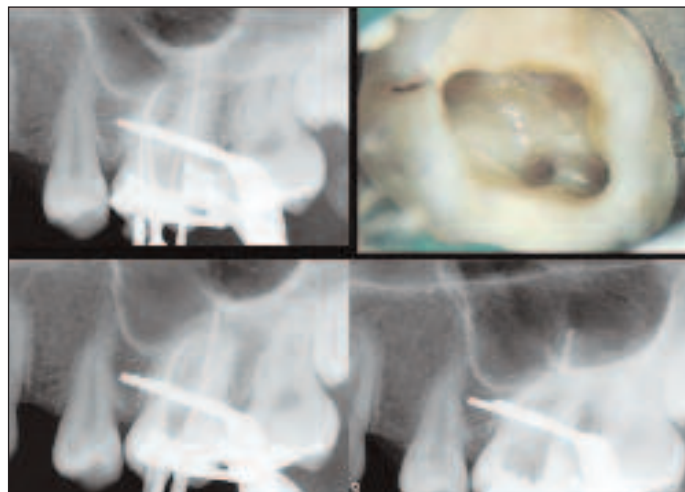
A radiograph is taken with the clamp on after downpack to ensure that no voids are visible and that the heating device has not inadvertently removed the apical part of the root filling
